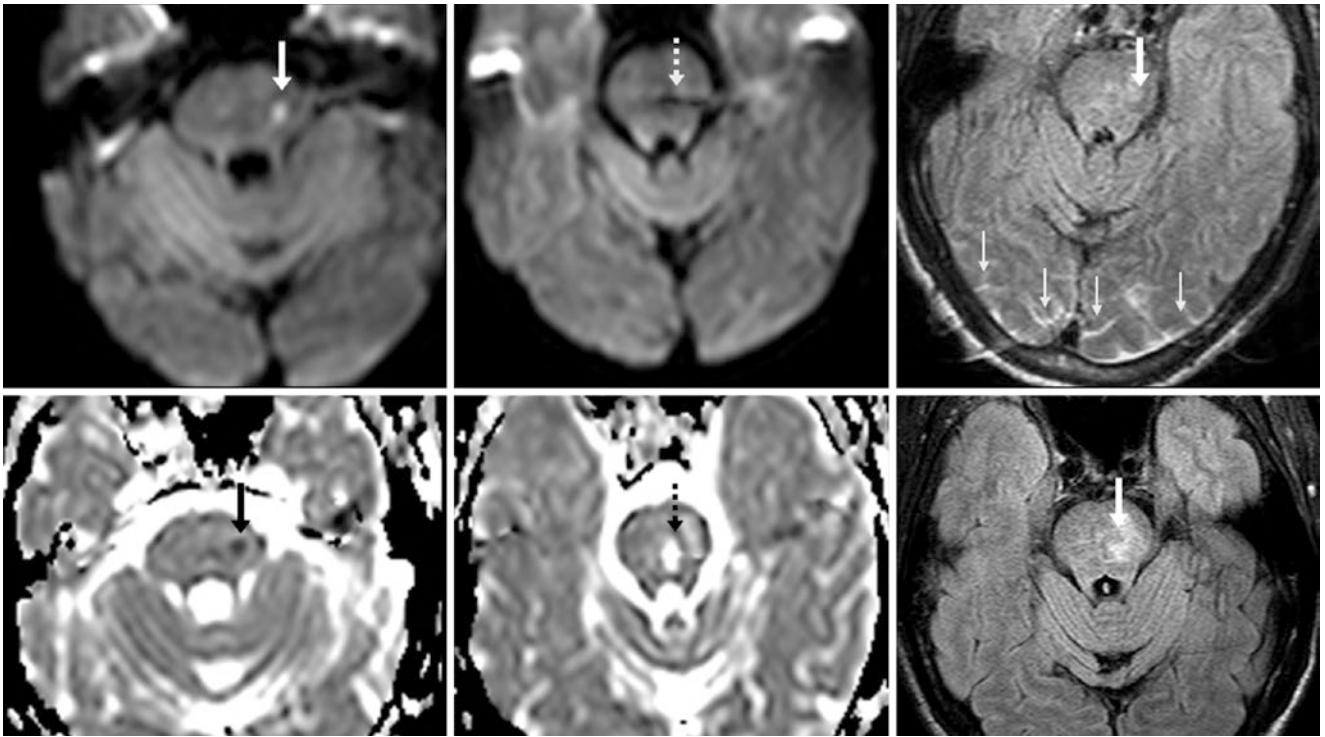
Comparison case of lacunar infarct combined with motion artifact. A 71-year-old with a 3 T MRI had focal bright signal within the left hemispheres (arrows) on DWI (top left); the image was dark on DWI at a level just above that (top middle). Motion artifact with resultant sulcal hyperintensity (thin arrows) was seen on FLAIR (top
